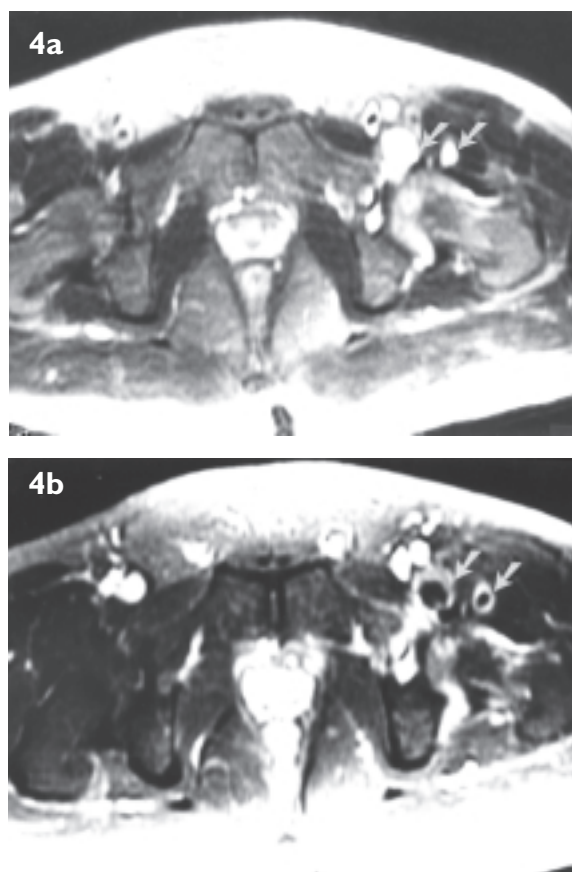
Primary iliopsoas abscesses in a 40-year-old woman with a known diagnosis of systemic lupus erythematosus on steroid treatment. a) Axial fast spin-echo T2-W MR image taken at the level of the hip joints shows multiple small rounded areas of high signal intensity (arrows) within the distal left iliopsoas muscle. (b) Enhanced axial spin-echo T1-W MR image taken at the same level as Fig. 4a shows a typical pattern of rim enhancement around the rounded lesions (arrows).
